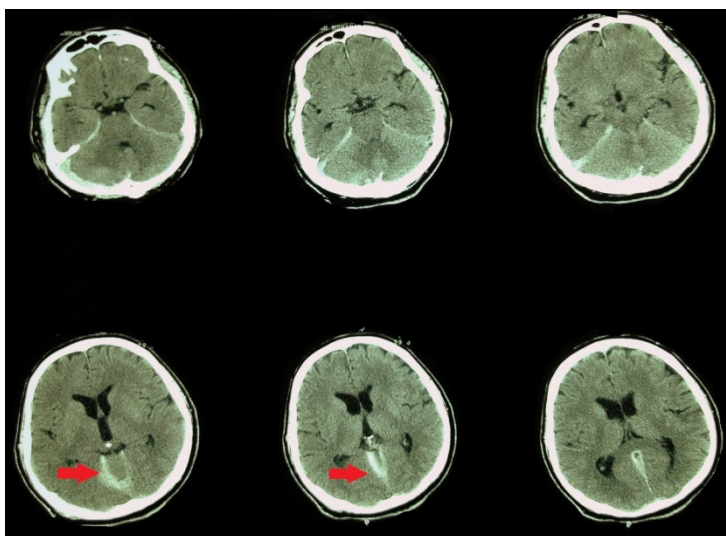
An urgent non-contrast CT brain scan of the patient at the time of Acute and Emergency department admission. Note that the right acute posterior fossa subdural hematoma is not that obvious (left upper slice at the level of mid-pons). However, the hyperdense blood at the tentorium cerebelli is remarkable (red arrows).
